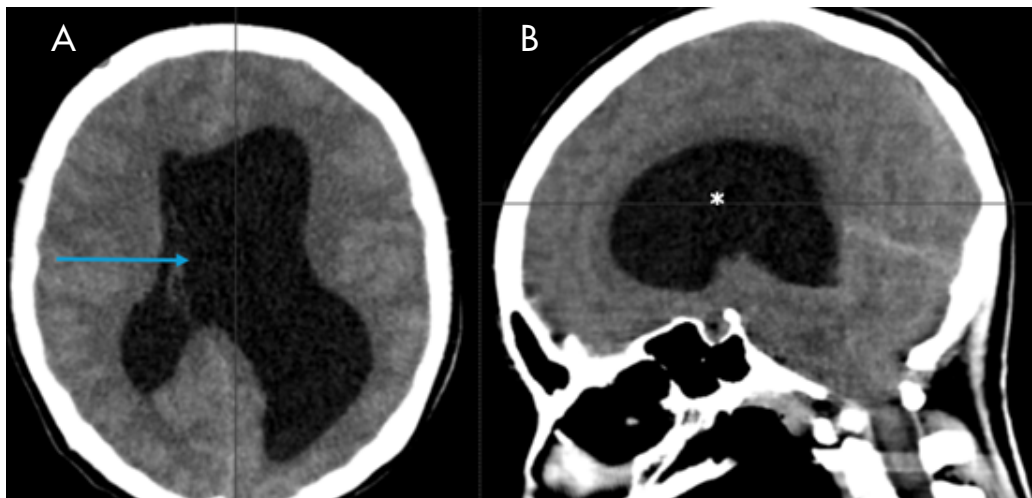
Non-contrast computed tomography scan of the skull (A: axial view; B: sagittal view) showing hypoplasia of the right lateral ventricle (arrow) and dilation of the supratentorial ventricular system (asterisk), findings consistent with stenosis of the aqueduct of Sylvius.
